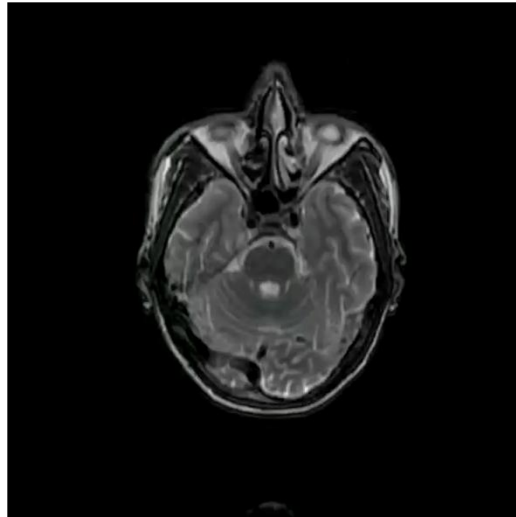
MRI image showing the full extent of the swelling in the head and neck region. These MRI results coincide with the clinical presentation of Kimura disease: involvement of parotid and submandibular glands is confirmed.
